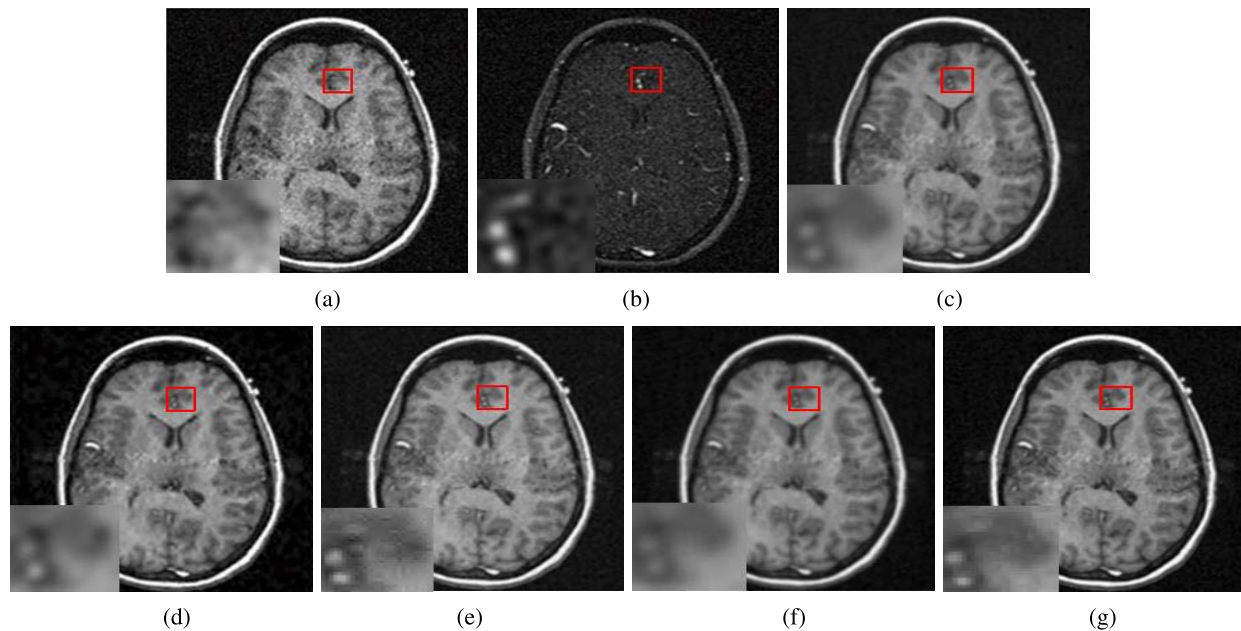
Input images that are added a 4.12-dB SNR and fusion result comparison with different methods. (a) Noisy T1-MR image. (b) Noisy MRA image. (c) SR. (d) NGWT. (e) TVPL. (f) BM3D+GFF. (g) Proposed method.
